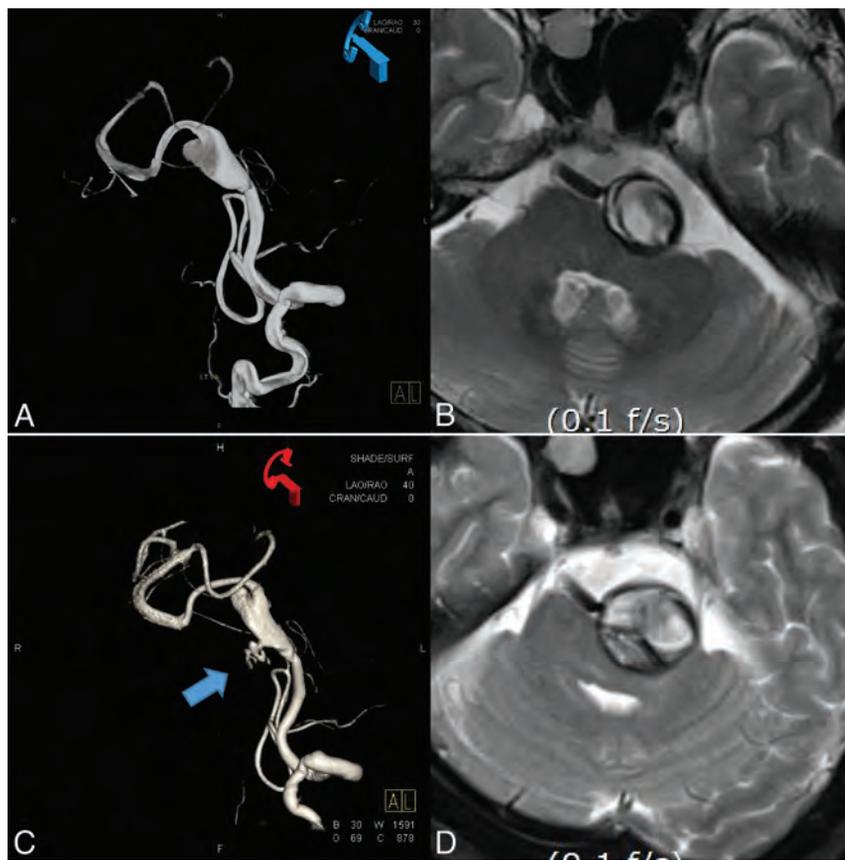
Growth of an observed vertebral artery dissecting aneurysm in a 67-year-old woman. *A*, 3D rotational angiography shows a fusiform-type vertebral artery dissecting aneurysm on the fourth segment of left vertebral artery. *B*, T2 axial MR image shows formation of intra-aneurysmal thrombus with brain stem compression. The patient underwent observation, and right-sided weakness developed after 5 years. *C*, 3D rotational angiography after 5 years shows contrast extension into the thrombosed aneurysm sac (arrow). *D*, T2 axial MR image shows enlargement of aneurysm diameter with aggravation of brain stem compression.
